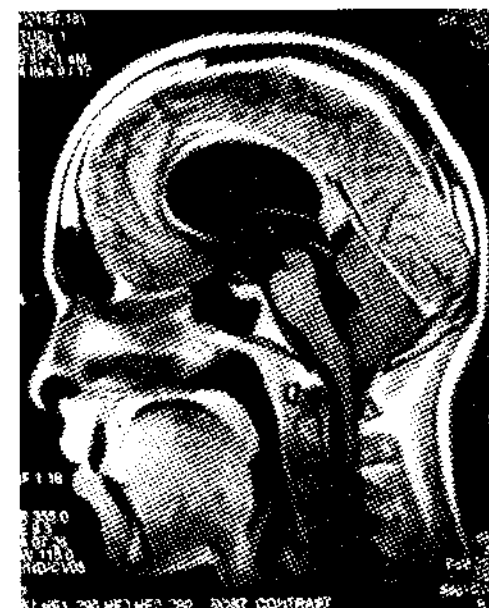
MRI images of patients with hydrocephalus
